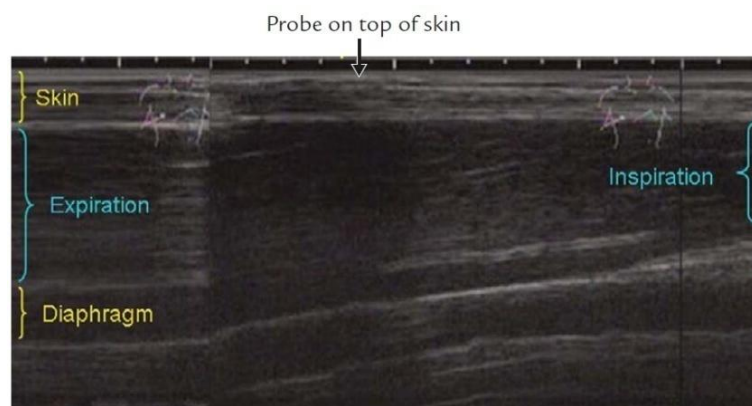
Ultrasound image obtained from the right-side abdominal rib cage, showing the diaphragmatic motion during inspiration and expiration phases [Wang 2009].
